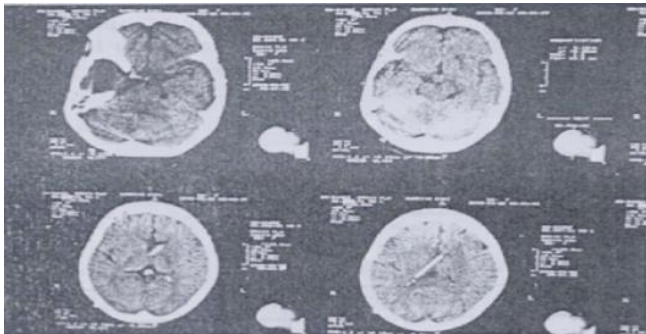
Postoperative CT Scan brain showing V.P. Shunt cerebellar clot had resolved.
